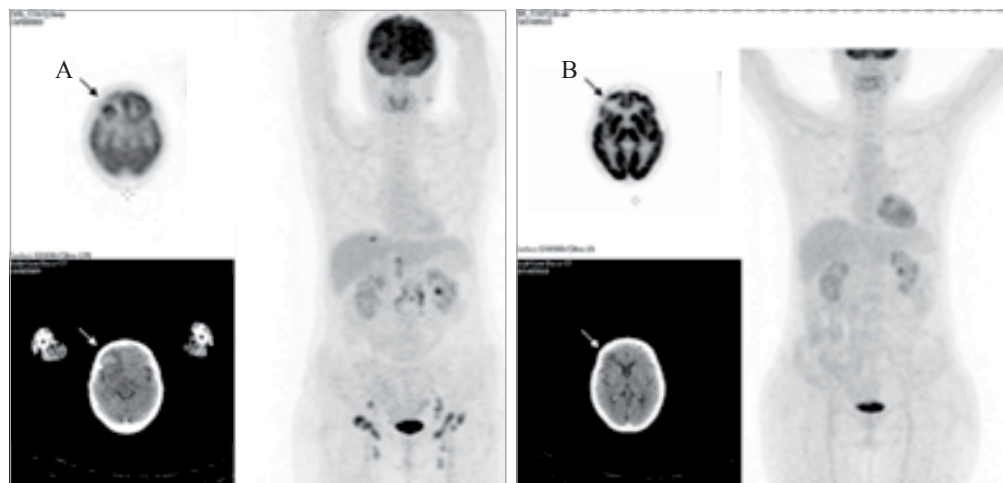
A. Patient No. 23 with ovarian cancer referred for restaging with ^{18}F -FDG PET/CT. The study revealed a solitary ring-like brain metastasis in the right frontal lobe (arrow), a solitary liver metastasis, paraaortal and inguinal lymph nodes involvement. B. The same patient after neurosurgery and chemotherapy. Postoperative changes in the brain (arrow). Complete metabolic remission of all extracranial lesions.
